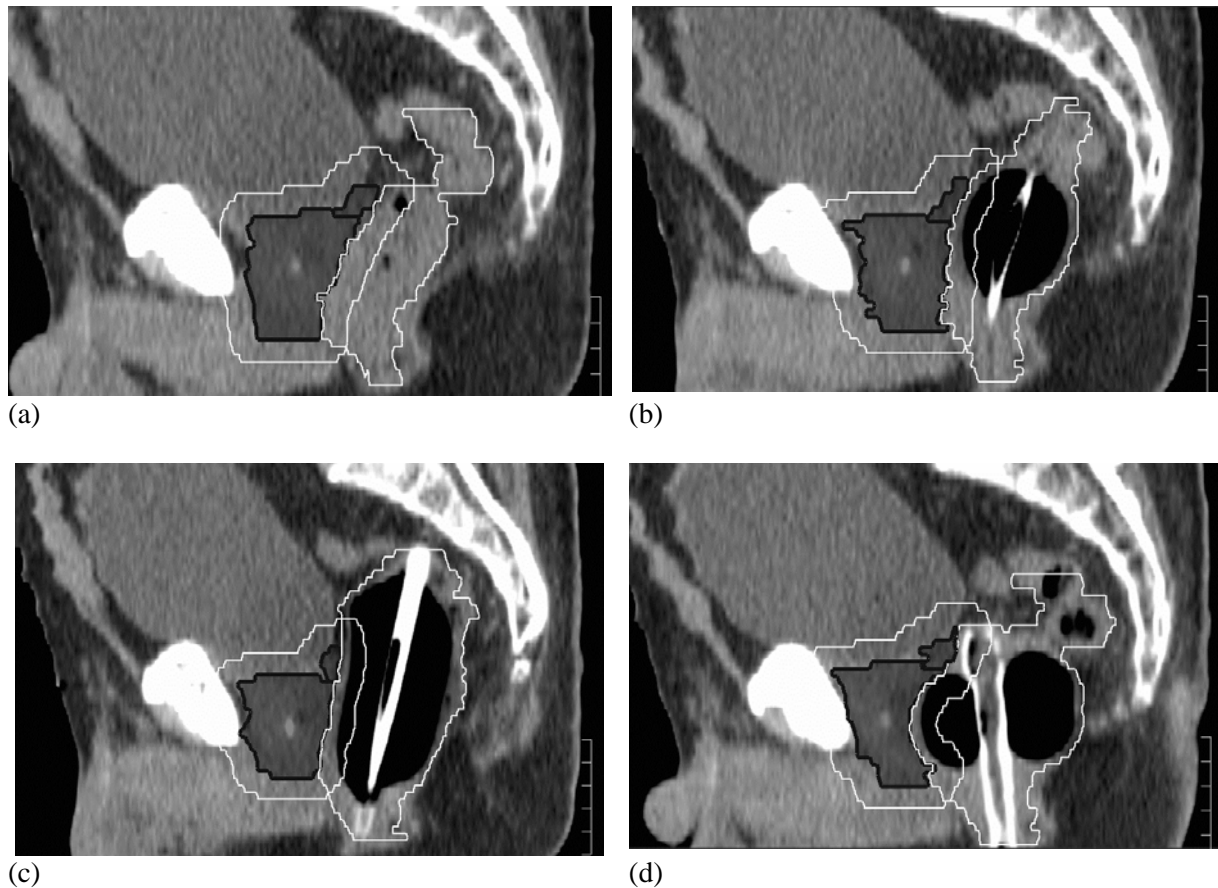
Sagittal CT images of a patient with (a) No ERB, (b) ERB1, (c) ERB2 and (d) ERB 3 inserted. Prostate, seminal vesicles and rectal outer contours are highlighted. The planning treatment volume surrounds the prostate and seminal vesicles.
